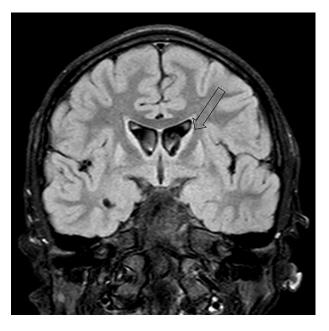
Coronal FLAIR reveals severe atrophy of the caudate heads (arrow).
